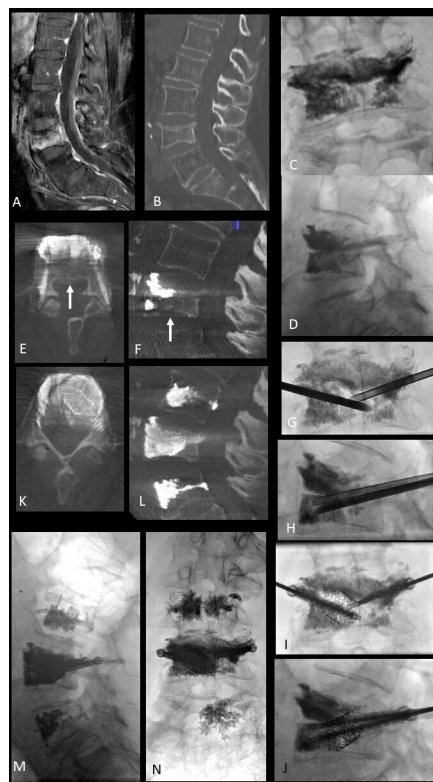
Patient 4. (A–B) MRI (contrast-enhanced fat-saturation T1) and CT scan showing fracture of superior endplate of L4, with bone marrow edema. (C–D) Fluoroscopic views after vertebroplasty of L4, performed with bilateral pedicular approach, with apparent good cement-filling. (E–F) CT scan obtained 25 days postoperatively due to pain recurrence, showing U-shaped distribution of cement and large 'bare area' in the center of the vertebral body and middle column (arrow on E), and a new coronal split fracture of inferior endplate, coursing along the junction between the anterior and middle column (arrow on F). (G–J) Procedural fluoroscopic views of transpedicular middle column stent-screw assisted internal fixation (SAIF) with left unilateral stent and bilateral transpedicular screws. Post-procedure flat panel CT (K–L) and 3 month follow-up upright fluoroscopic views (M–N) showing fracture reduction and bridging with the stent-screws-cement complex at L4.
